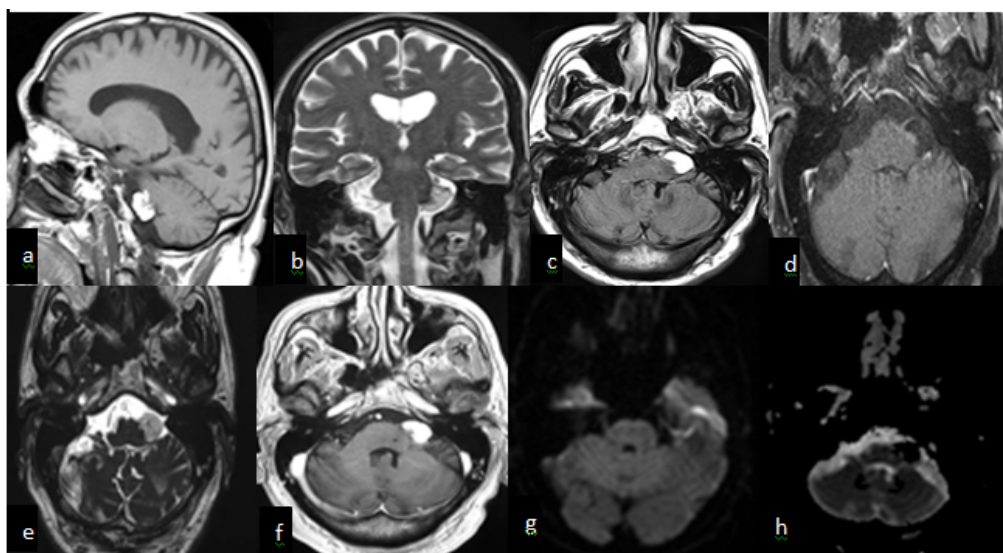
Left CPA lipoma. (a,b,c) well defined mass lesion shows a high signal on T1, T2 and FLAIR with (d) signal dropout on fat suppressed t1 weighted post contrast sequence with low signal margin on steady state axial image. (e) no post contrast enhancement of T1 weighted post contrast images. (f,g) no obvious diffusion restriction on DWI and corresponding ADC low map images
